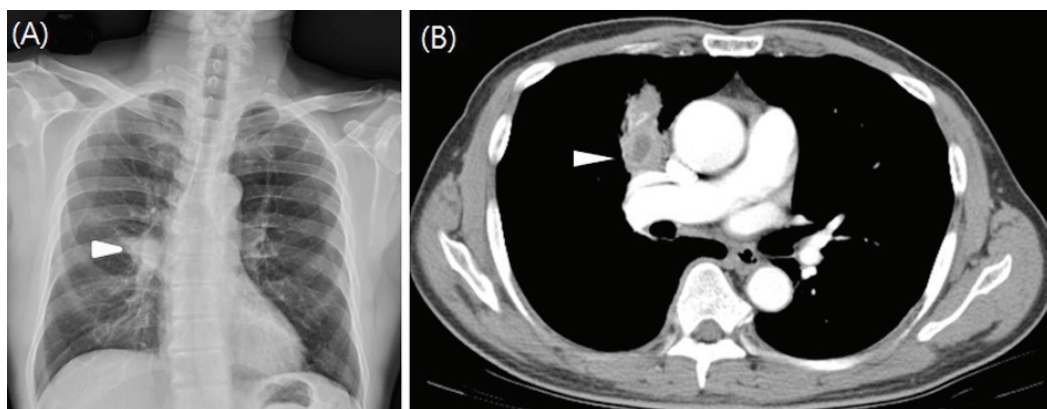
The initial chest radiograph showed a right hilar mass (arrowhead) (A), and chest computed tomography (CT) revealed a lobulated heterogeneously enhancing mass (arrowhead) at the anterior segment of the right upper lung (B).
